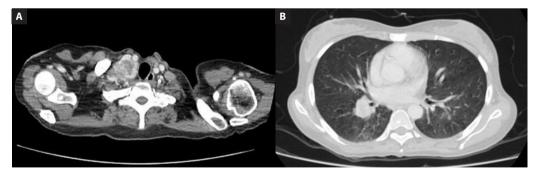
Axial CT images showing (A) right supraclavicular necrotic lymph node (B) right hilar nodule
